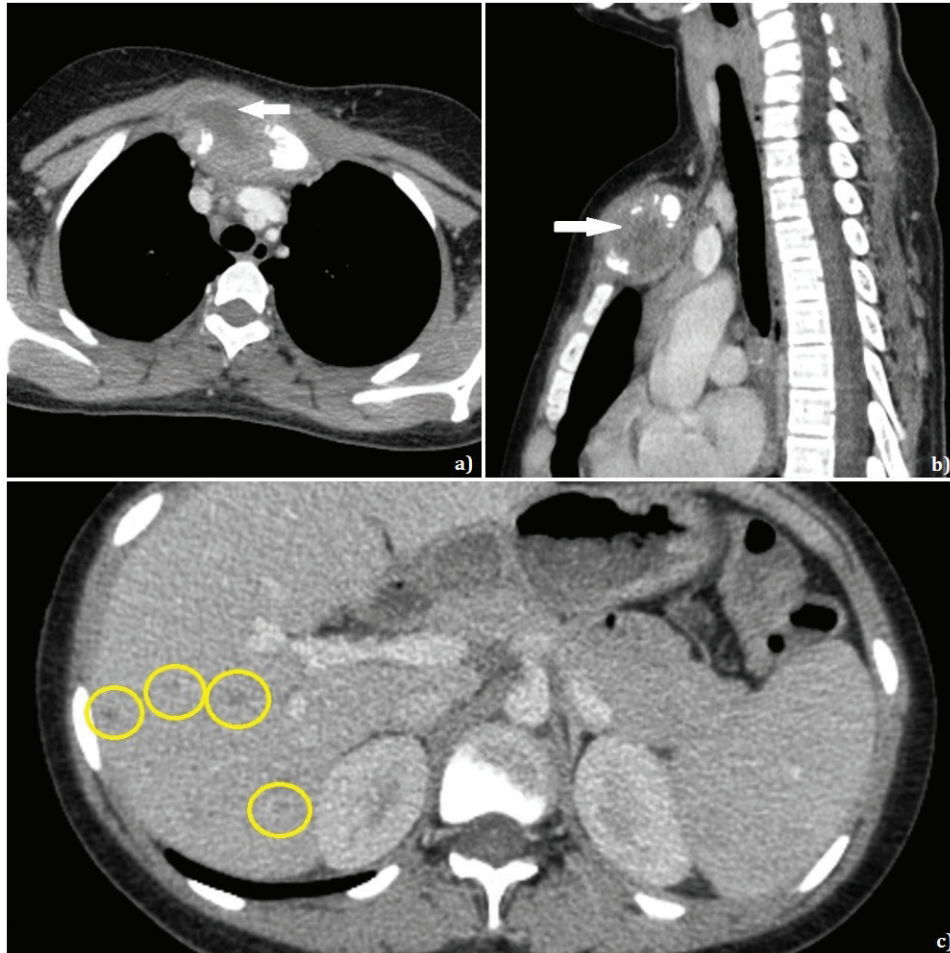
Computed tomographic examination of the chest revealed: axial section (a) and sagittal section (b) showing osteolytic destruction of the manubrium with formation of abscess (arrow) and (c) axial section of upper abdomen showing multiple tiny hypodense nodules in right lobe of liver (yellow circles).
